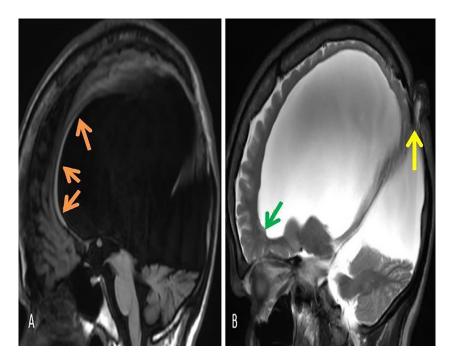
Magnetic resonance imaging of brain sagittal sections T1 weighted imaging (A) and T2 weighted imaging (B) shows hypoplastic corpus callosum, ie, genu and body, with non-visualization of splenium (orange arrows). A bony defect is seen in the posterior parietal bone with herniation of cerebrospinal fluid and meninges through the defect (yellow arrow). Subependymal nodule noted (green arrow).
